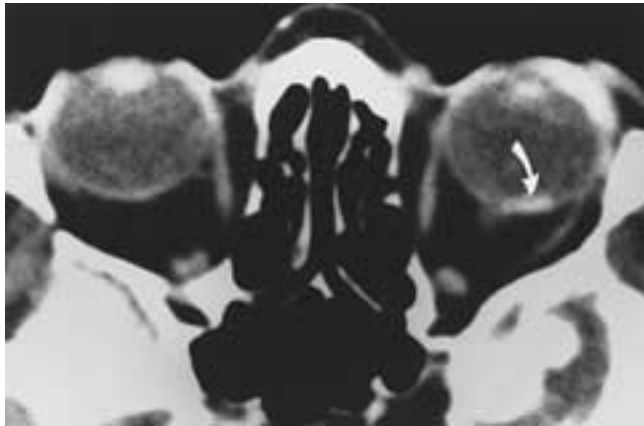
Senile macular degeneration. Axial PW MR image shows a hyperintense mass (*arrow*) compatible with discoid macular degeneration. The lesion remained mixed in signal intensity on a T2-weighted image with a small, ill-defined area that appeared hypointense.
